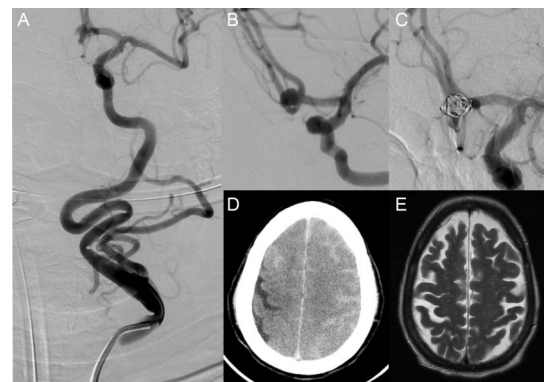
(A) Left common carotid angiography showing marked tortuosity of the left internal carotid artery. (B) The working angle projection delineates a 7 mm left anterior communicating artery aneurysm. (C) Postembolisation images showing obliteration of the aneurysm. (D) Postembolisation head CT scan demonstrating contrast enhancement and cerebral oedema. (E) Brain MRI 3 months after the procedure displays complete resolution of cerebral oedema.
